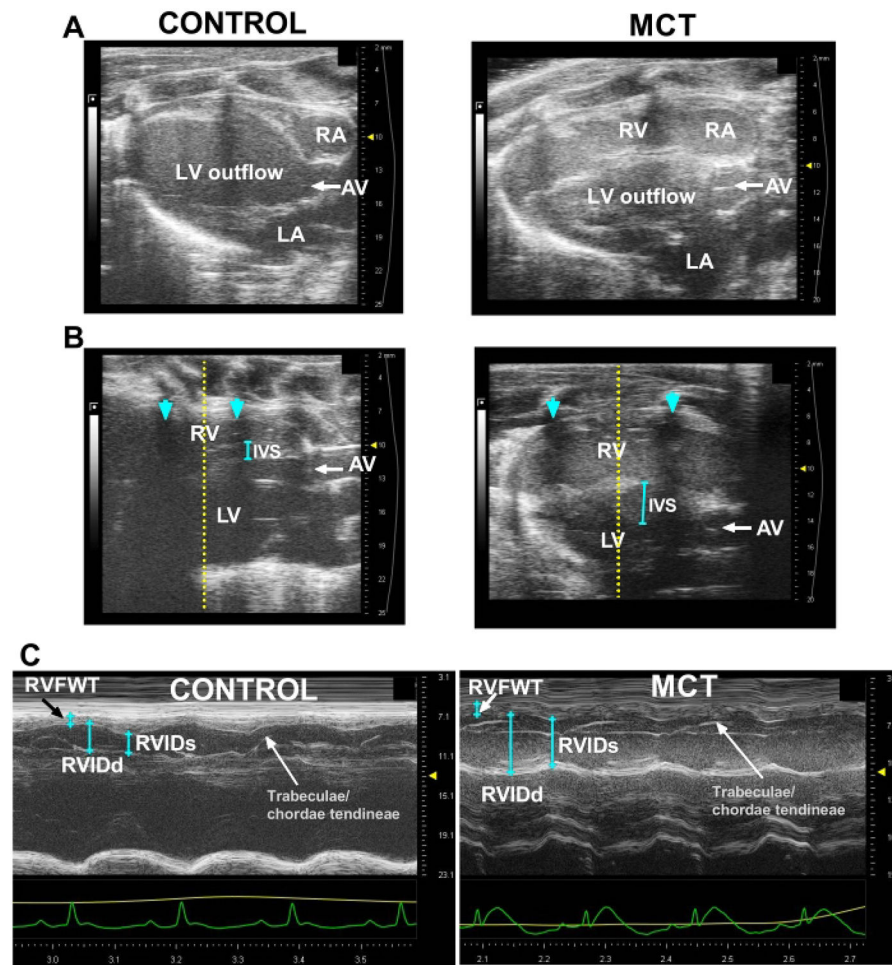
Parasternal long-axis (PLAX) views.
